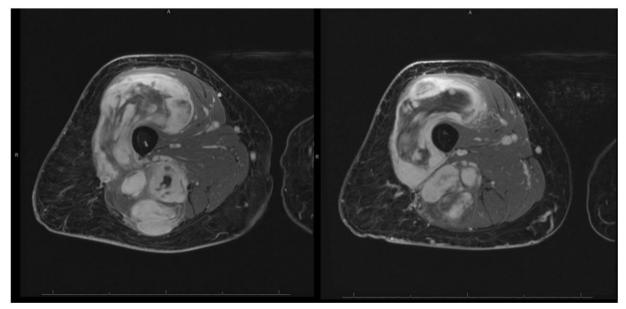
Two axial cuts in MRI with contrast showed the mass surrounding the femur and involving anterior, lateral, and posterior thigh compartments.
